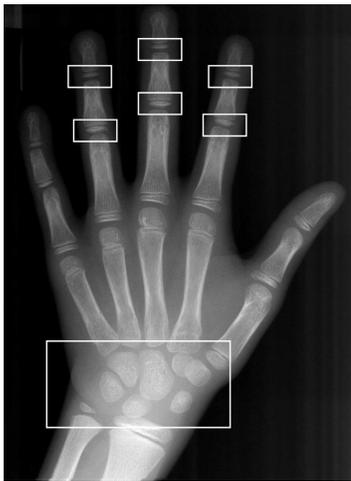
A left hand and wrist radiograph with seven regions of interest (ROI). Top: Six epi-metaphyseal ROIs; Bottom: Carpal bones ROI
